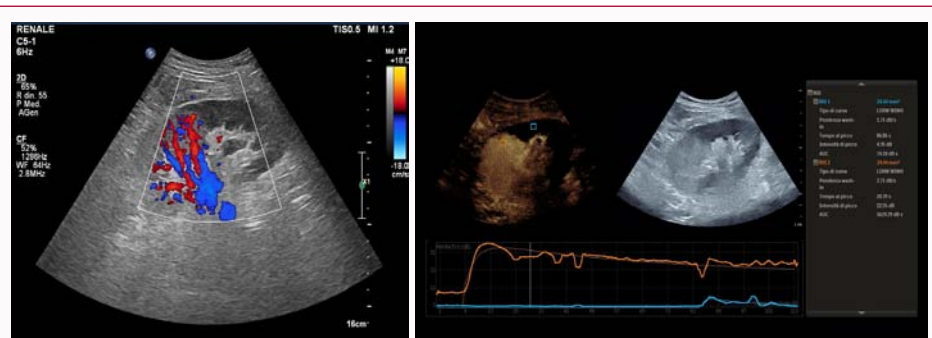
Postoperative follow-up echo-color-Doppler (A) and contrast enhanced ultrasonography (B).
